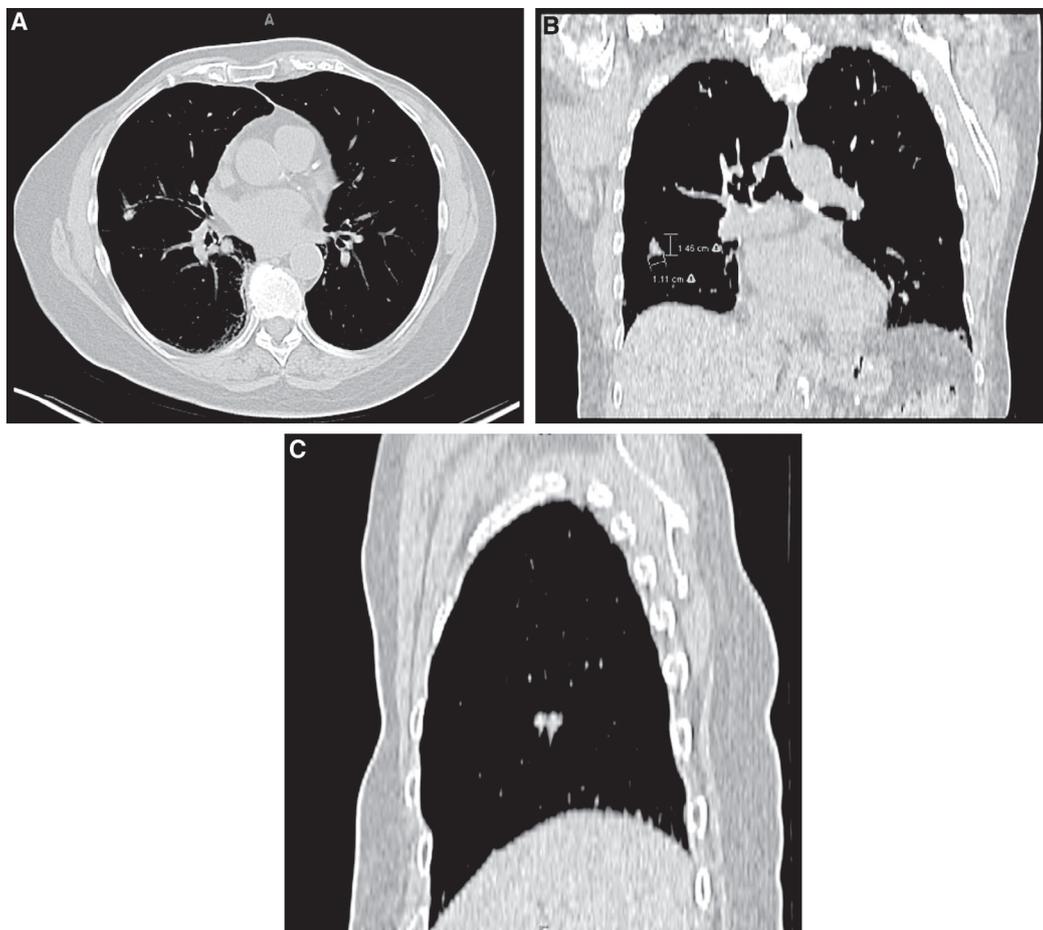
Panels A, B and C show computed tomography images of a patient with a small moderately differentiated (G2) adenocarcinoma with bronchoalveolar features. This patient was staged as T1N0M0.
